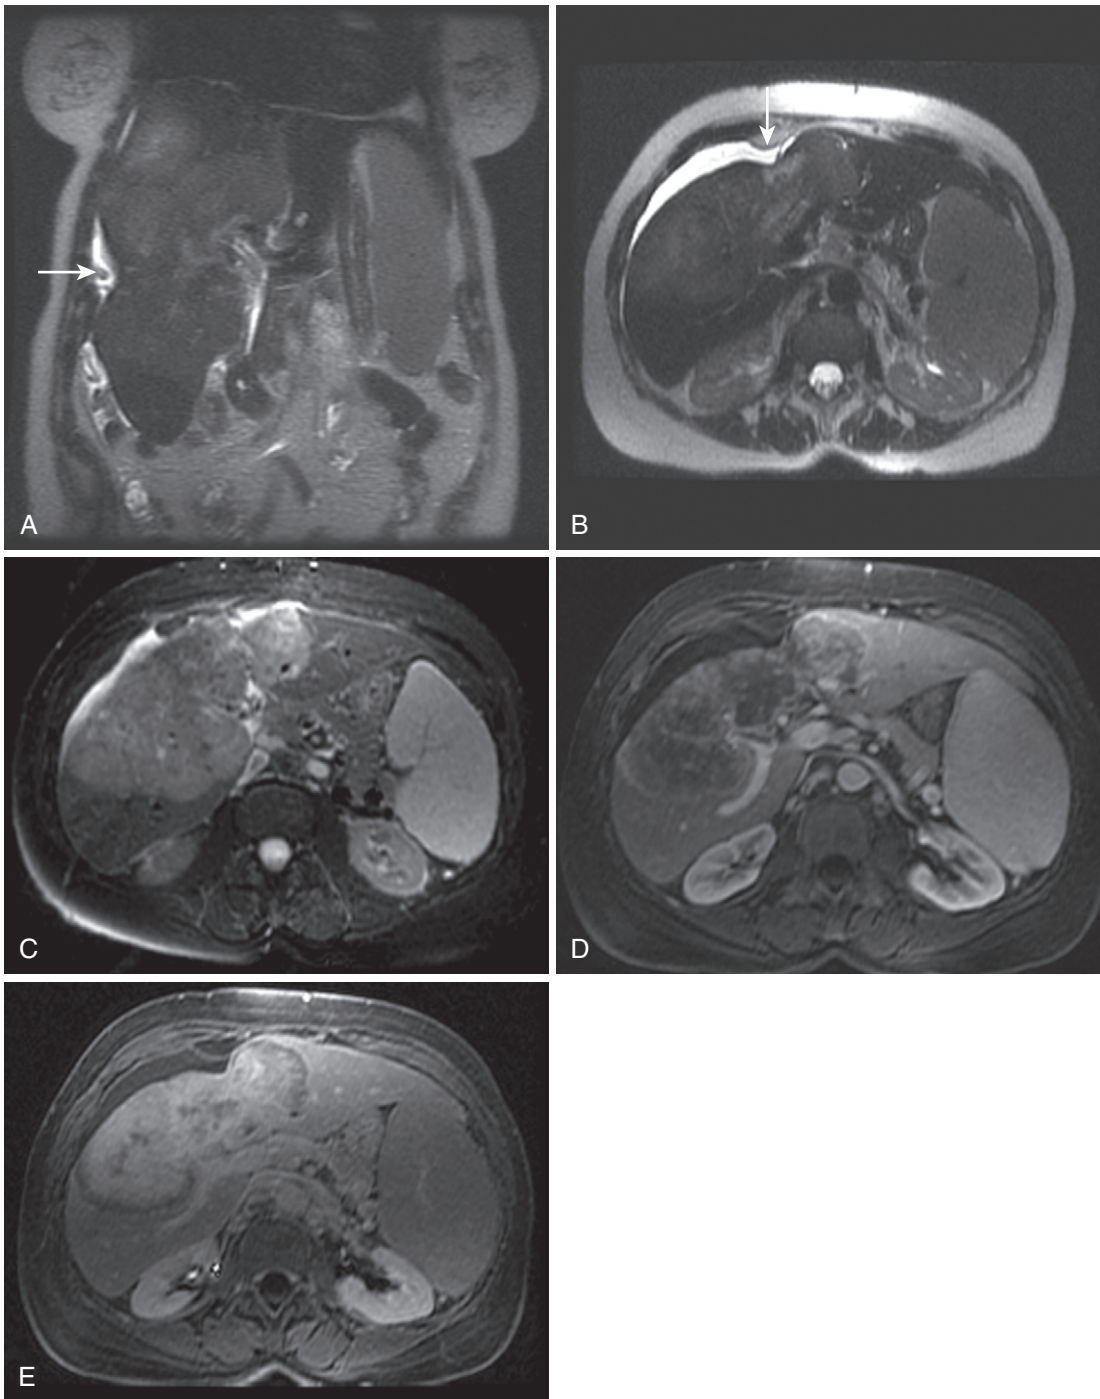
Cholangiocarcinoma with capsular retraction. Coronal (A) and axial (B) heavily T2-weighted and fat-suppressed moderately T2-weighted (C) images show a large mildly hyperintense lesion bridging the right and left hepatic lobes with convexity of the outer liver margin, indicating capsular retraction (*arrow* in A and B). Arterial phase (D) and delayed (E) images after contrast portray the typical hypovascular enhancement pattern with delayed, centripetal progression.
